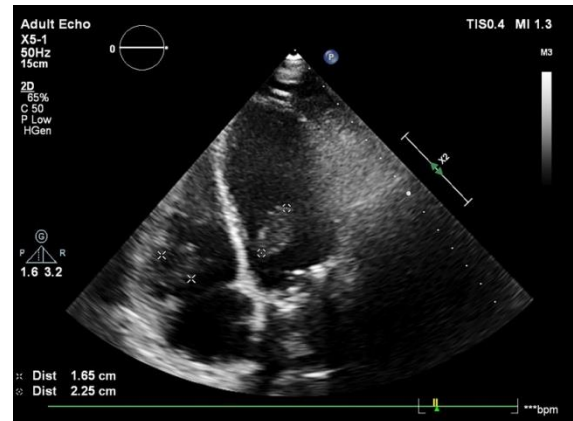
The apical 4-chamber view of the echocardiogram showing a solid mass (25x20 mm) in the left ventricle that infiltrated the septum with thin pedicles and a solid mass (20x17 mm) extending over the right ventricular tricuspid lateral valve
